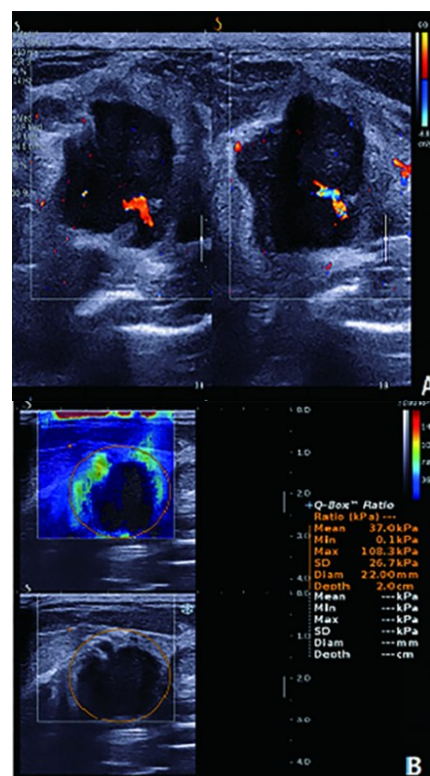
B-mode (A) US and SWE images (B) of invasive ductal carcinoma in a 56-year-old woman. The Emax, Emean, and SD were automatically measured by the system. The ROI was set sufficiently large to include the largest possible part of the mass and the surrounding breast parenchyma tissue. ROI, region of interest; SD, standard deviation; SWE, shear wave elastography; US, ultrasound.
